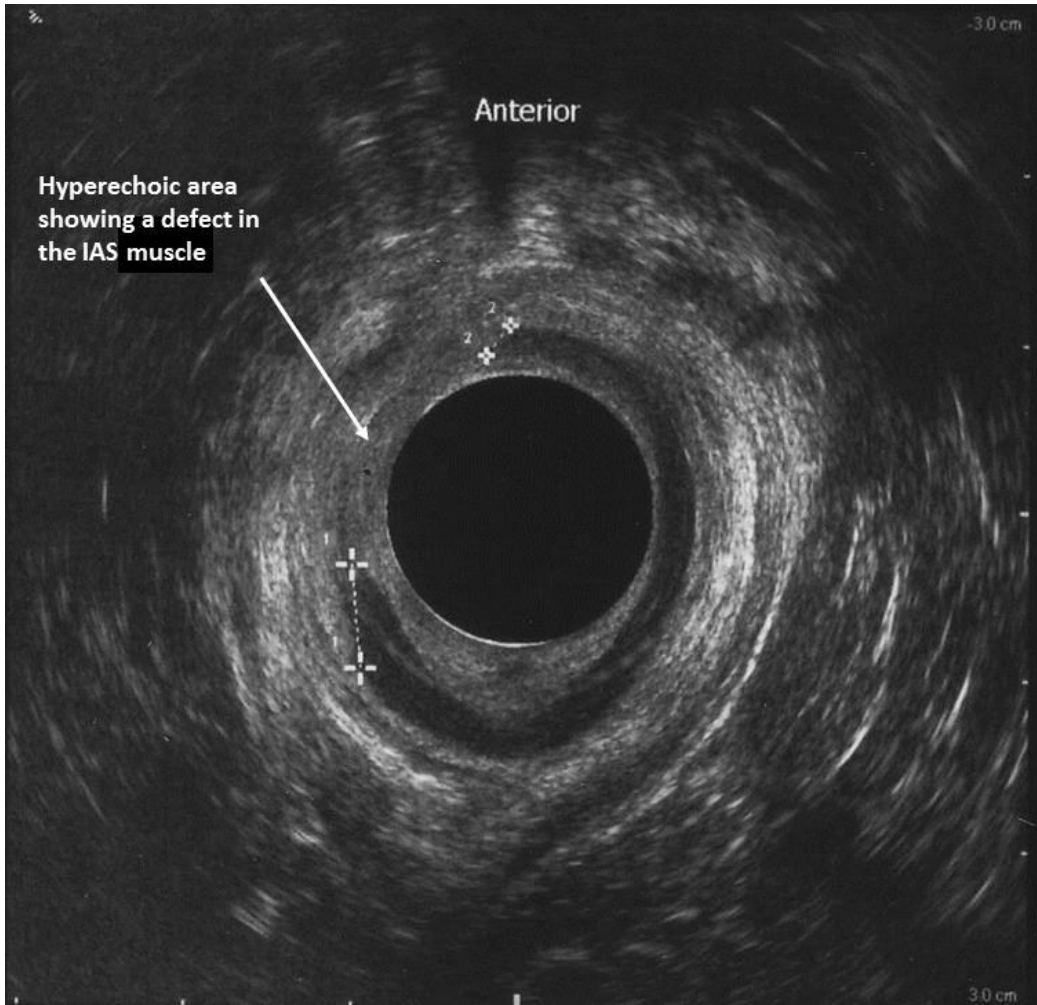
Ultrasound image of a defect in the internal anal sphincter
